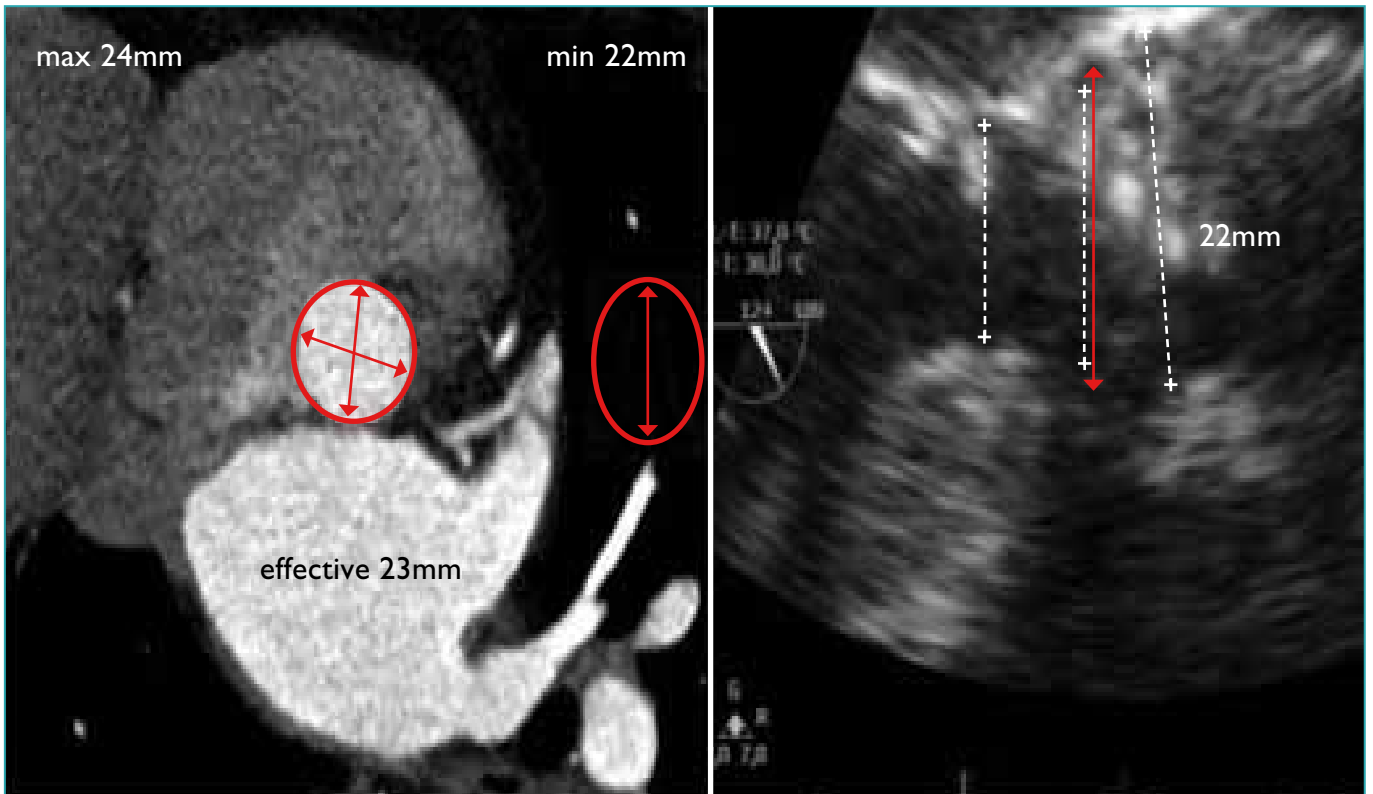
Measurement of the aortic annulus diameter using CT and TEE.
